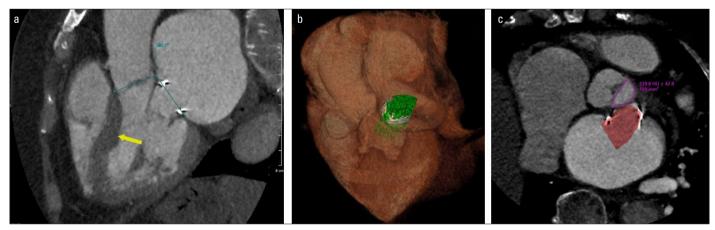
a. Gated computed tomography (CT) revealed a very unfavorable AMA and a large septal bulge, which increase the risk of LVOT0. b. CT showing virtual modeling of the 26-mm Myval valve deployment. c. CT showing predicted neo-LVOT area using virtual 26-mm Myval to be 169 mm²
